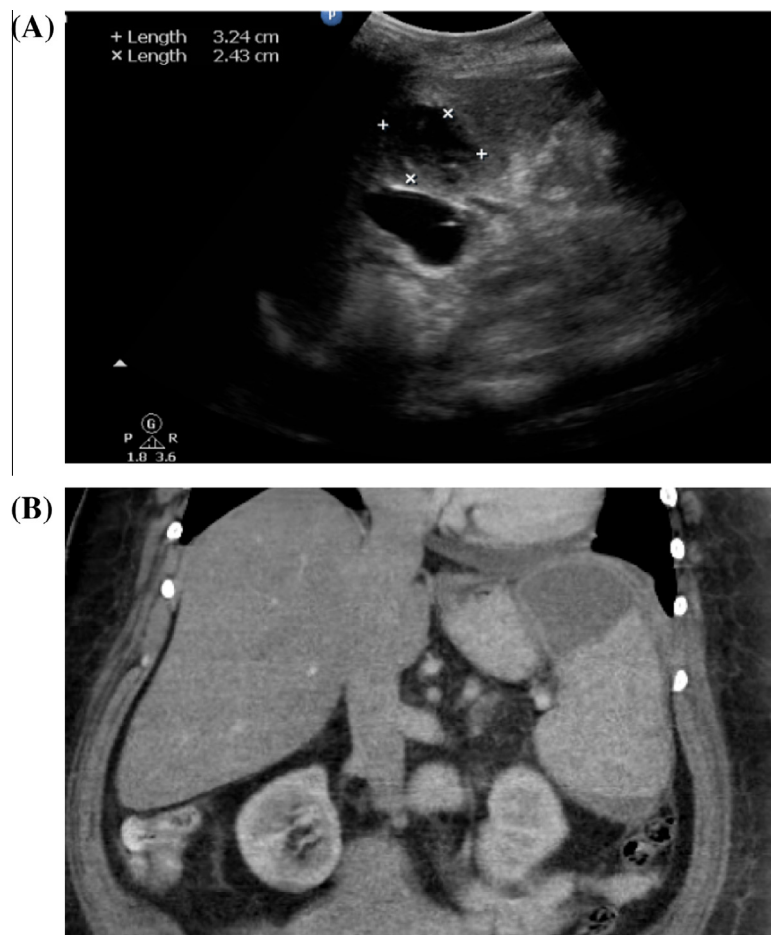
(A) Case 1: Ultrasound abdomen showing partially defined anechoic avascular cystic lesion in the spleen, measuring 3.2×2.4 cm, likely representing a splenic abscess. (B) Case 1: Computed tomography (CT) scan of the abdomen showing enlarged spleen with large splenic lesion, likely representing an abscess.
